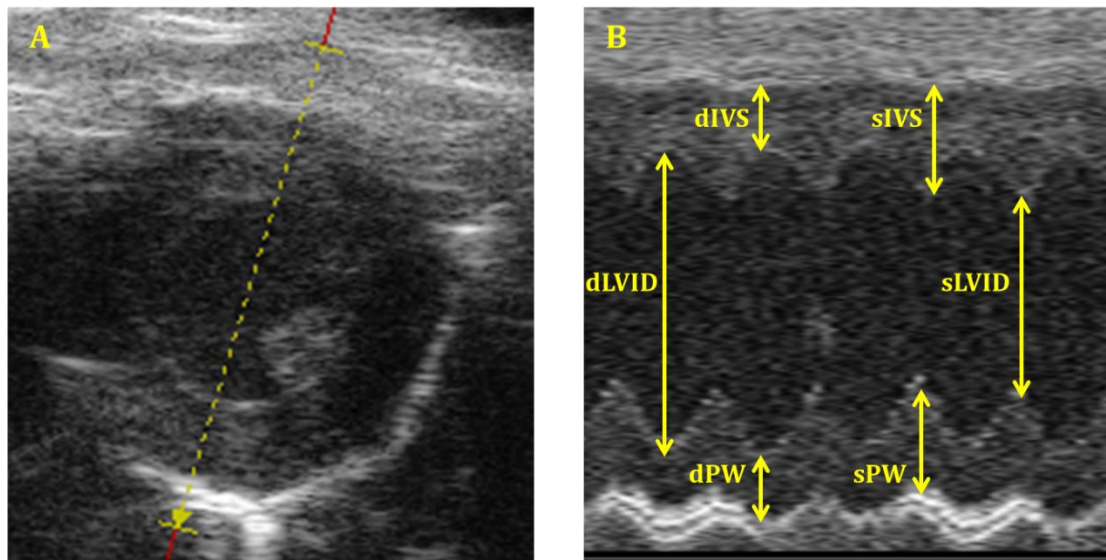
A short-axis M-mode image of the left ventricle A. An image taken in the short-axis view. B. Echocardiography parameters measured from the left ventricle in both diastole (d) and systole (s).
